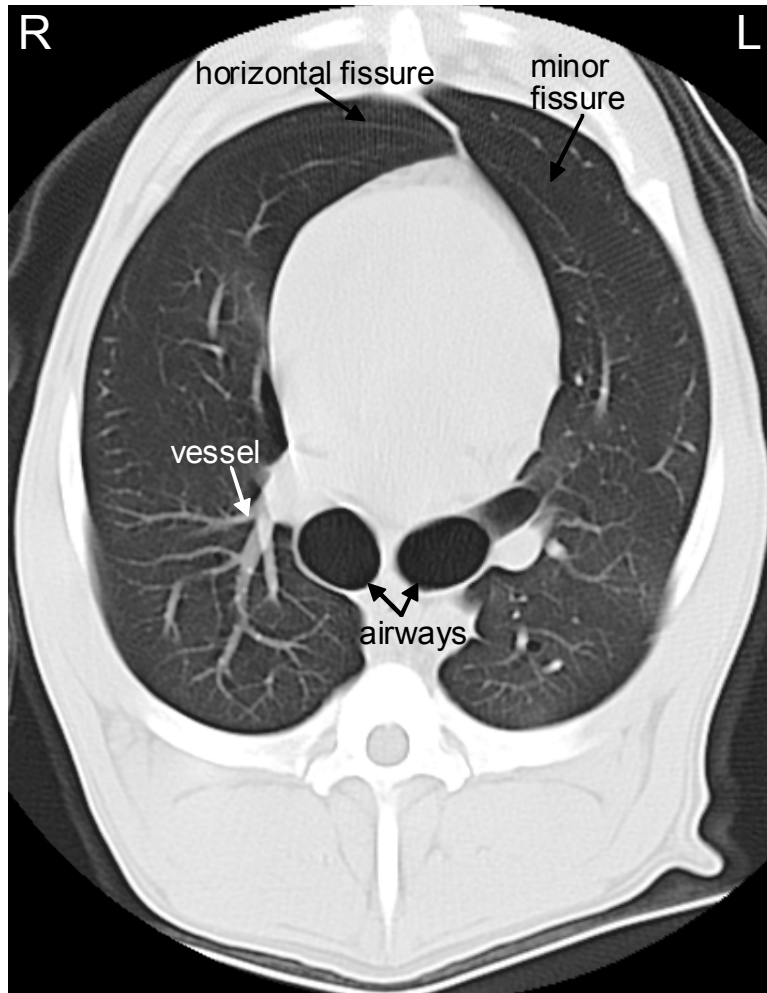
A thin slice spiral CT image on a transverse view
